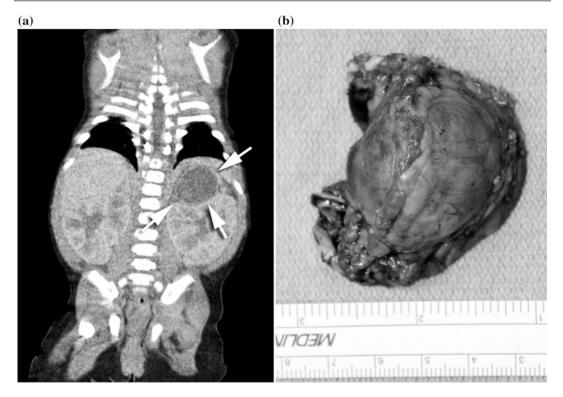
a CT Scan demonstrated a left adrenal mass consistent with an ACT (*white arrows*). b An open left adrenalectomy was performed which confirmed an ACT
